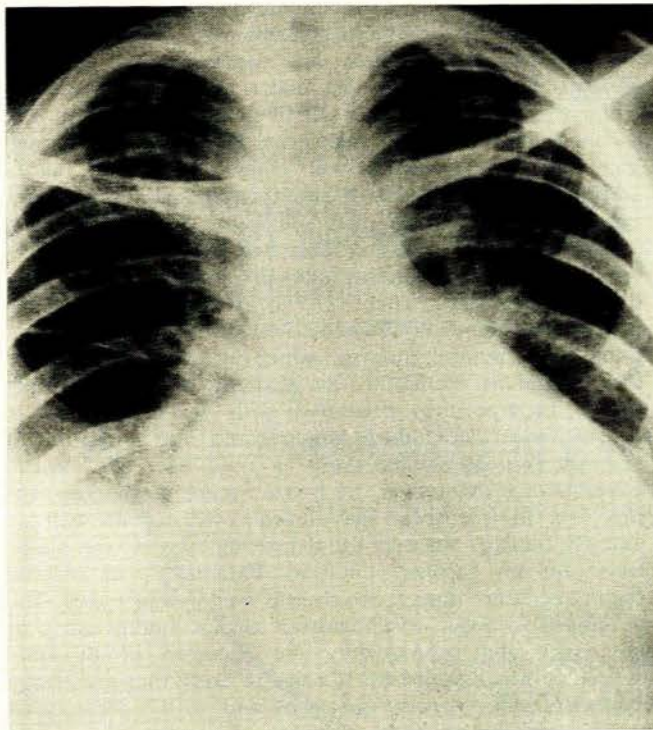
PA radiograph of chest showing cardiomegaly, pleural effusion and pulmonary congestion (Patient 9).
